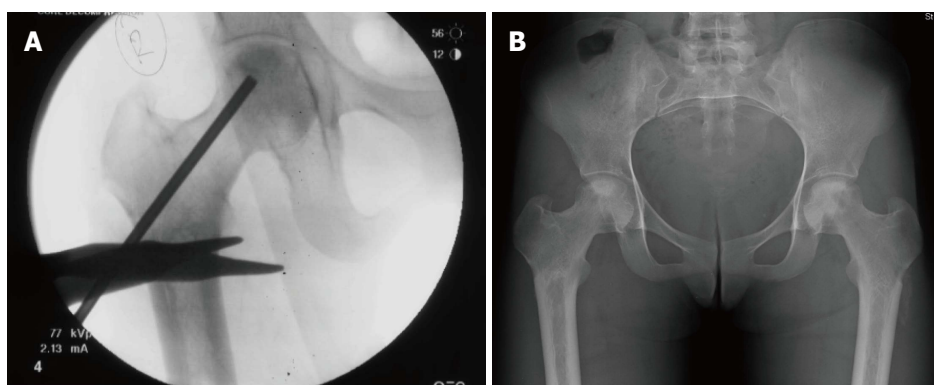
Intra-operative anterior-posterior fluoroscopic view (A) during a core decompression of the right hip, post-operative anterior-posterior radiograph of the pelvis (B) after bilateral core decompression.
